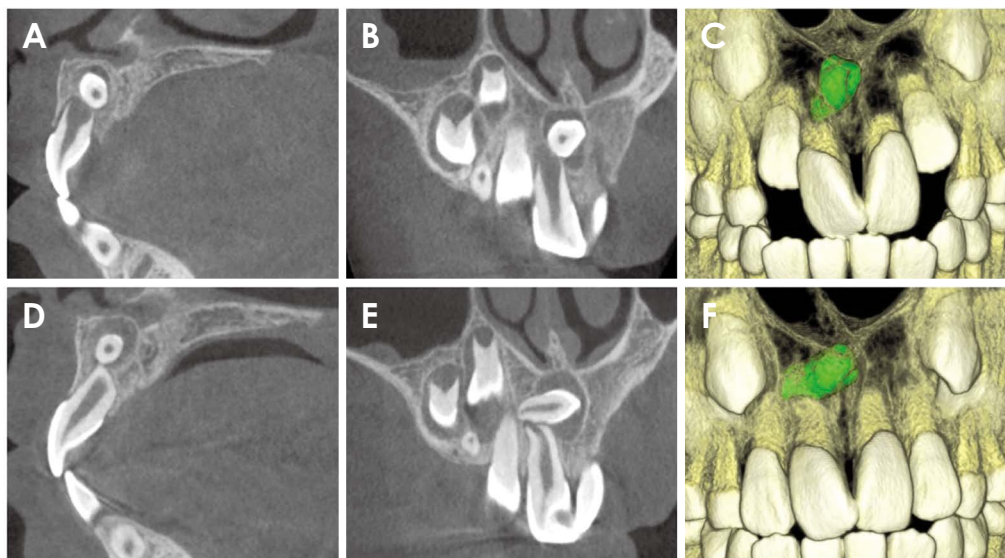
A case shows the development of mesiodens-related complication over time. In a 7-years-old patient's sagittal (A), coronal (B), and 3-dimensional (C) cone-beam computed tomographic (CBCT) images taken from, a mesiodens is in a horizontal posteroanterior direction and in direct contact with the apex of immature permanent maxillary right central incisor. In the respective CBCT images (D-F) taken 1 year later, the mesiodens changes its direction toward the midline and the abnormal root formation of the right central incisor is seen.
